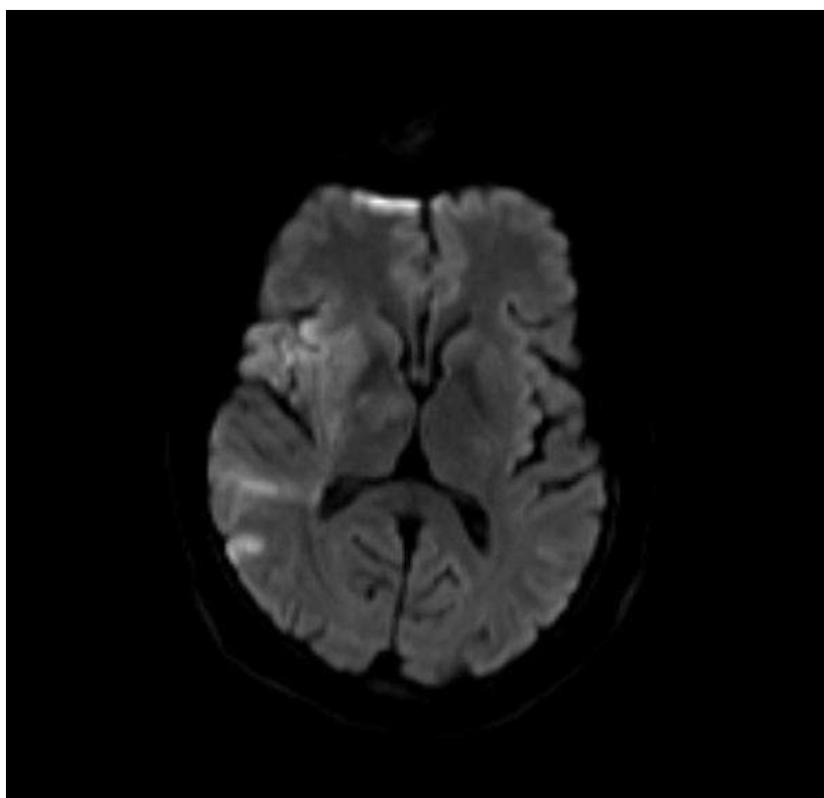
Right fronto-parietal acute infarct on diffusion weighted MRI imaging.
